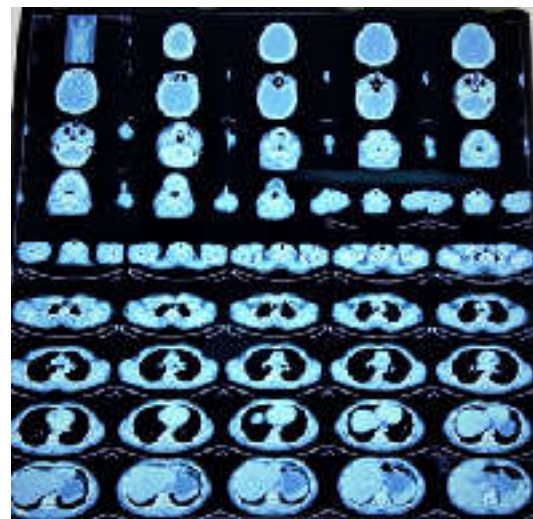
4. PET-CT showing gross lymphadenopathy
